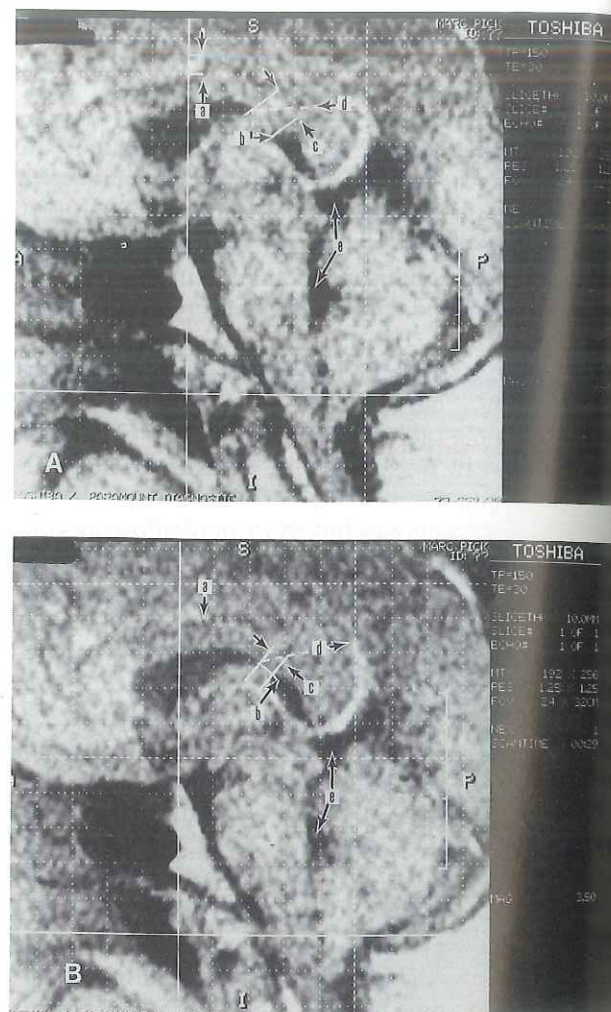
Midsagittal MRI performed at magnification 1.60; the arrows depict areas of investigational focus. *A.* First MRI scan performed with the investigator's contacts positioned but without the application of cranial manipulative force. *B.* Second MRI scan performed during the investigator's application of firm manipulative pressure toward the opposing contact point.
